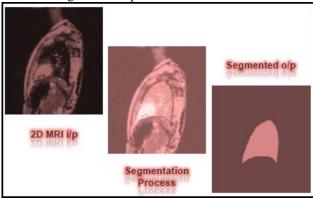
Segmentation using LWOF and Paint was done on 2D MRI with the help of 3DVIEWNIX tool.
